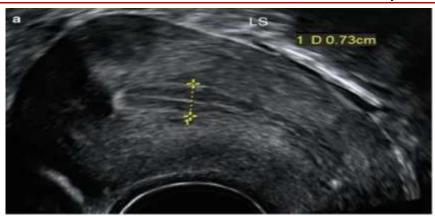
Measurement of Endometrial Thickness Using Transvaginal Ultrasonography
